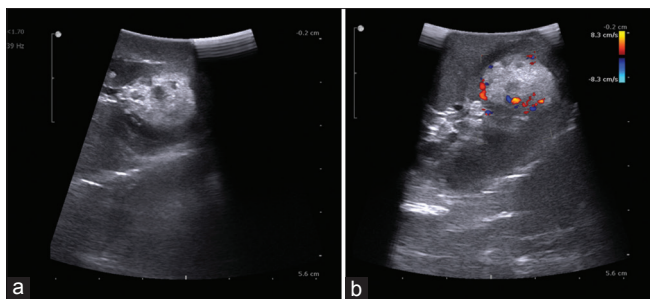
Real-time images of intraoperative laparoscopic ultrasonography in laparoscopic partial nephrectomy. (a) B-mode imaging. (b) Color Doppler imaging
